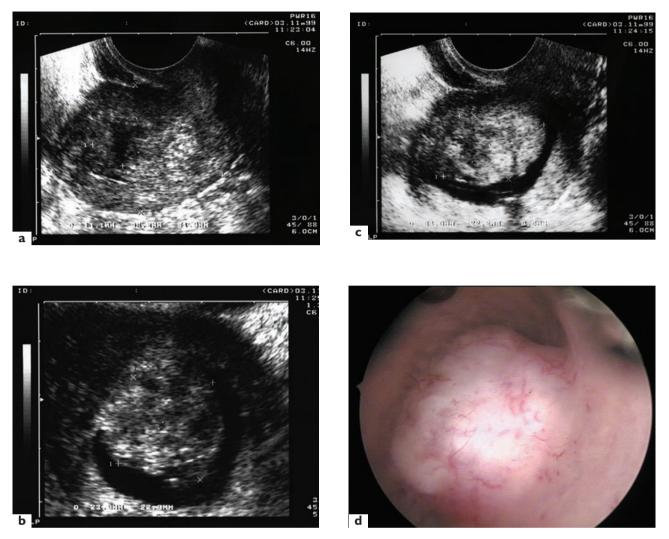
A 40-year-old patient with menorrhagia. (a) Transvaginal sonography, sagittal view, shows the normal uterine size, and suspicion of a mass effect inside the uterus with irregular limits; (b) and (c) saline infusion sonohysterography provides visualization of a pure submucosal myoma of 22×22 mm; (d) hysteroscopic view (note atrophic endometrium due to gonadotropin releasing hormone (GnRH) agonist treatment)
